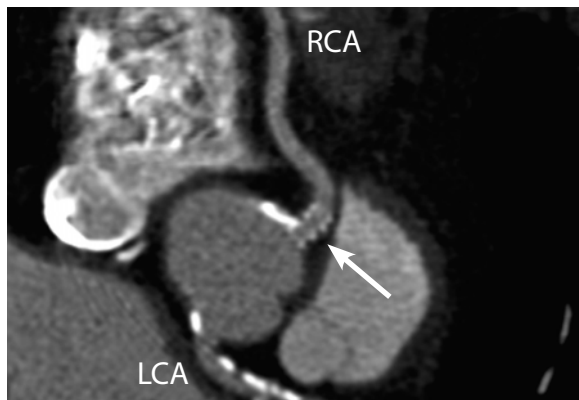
Low-opaque stent (arrow) in the ostium of the RCA, visualized with curved MPR. There is practically unhindered interpretability of the vessel lumen, which was imaged with 16-slice CT. LCA Left coronary artery
